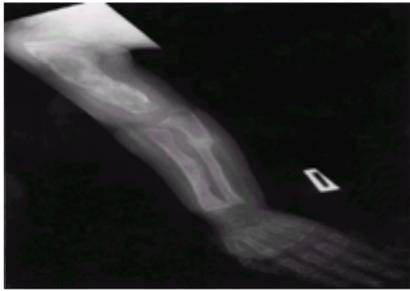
Pathological fractures in a 2-year-old boy with osteogenesis imperfecta. Radiograph shows multiple fractures, diffuse decreased bone density, and transverse radiolucent metaphyseal bands.
